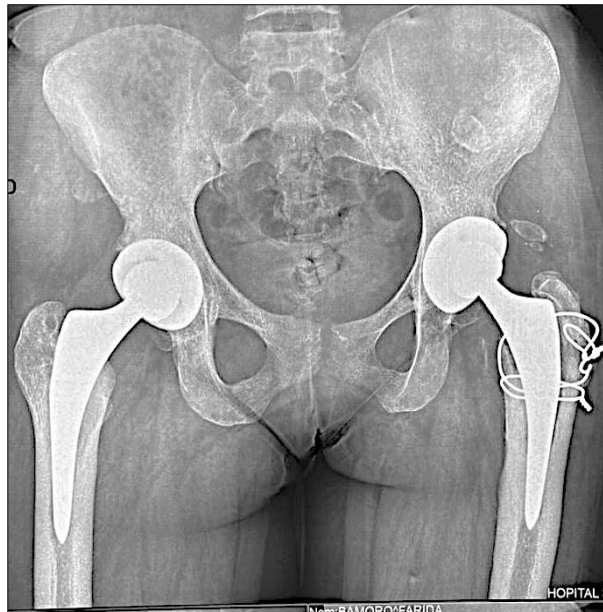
Radiographic appearance of a THA at final follow-up
